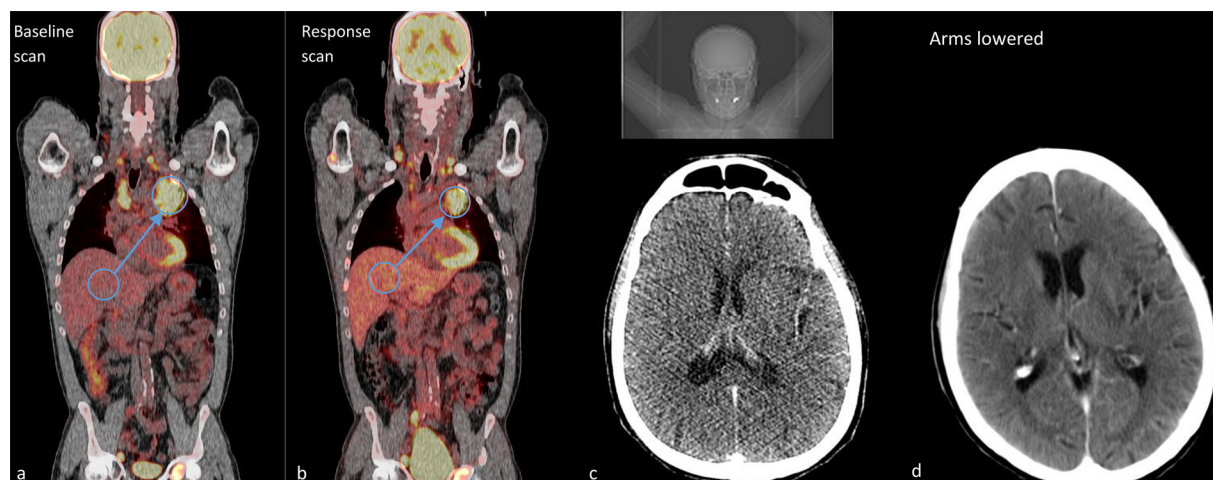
a) Baseline ^{18}F -FDG-PET/CT scan of the NCT01171170 trial; b) Response ^{18}F -FDG-PET/CT scan of the same patient, showing that a different SUV_{mean} of the liver can lead to a visually underestimation of response in the tumor; c) Axial CT image of the brain of the NTR3628 after contrast administration, reconstructed with a field of view of 500×500 mm with raised arms (note the high level of noise and the streak artifacts due to beam hardening); d) Axial CT image of the brain of the same patient at approximate the same level, also after contrast administration, reconstructed with a FOV of 200×200 mm with the arms lowered. The window and level setting are identical as well as other acquisition parameters for all imaging, note the difference in image quality.
